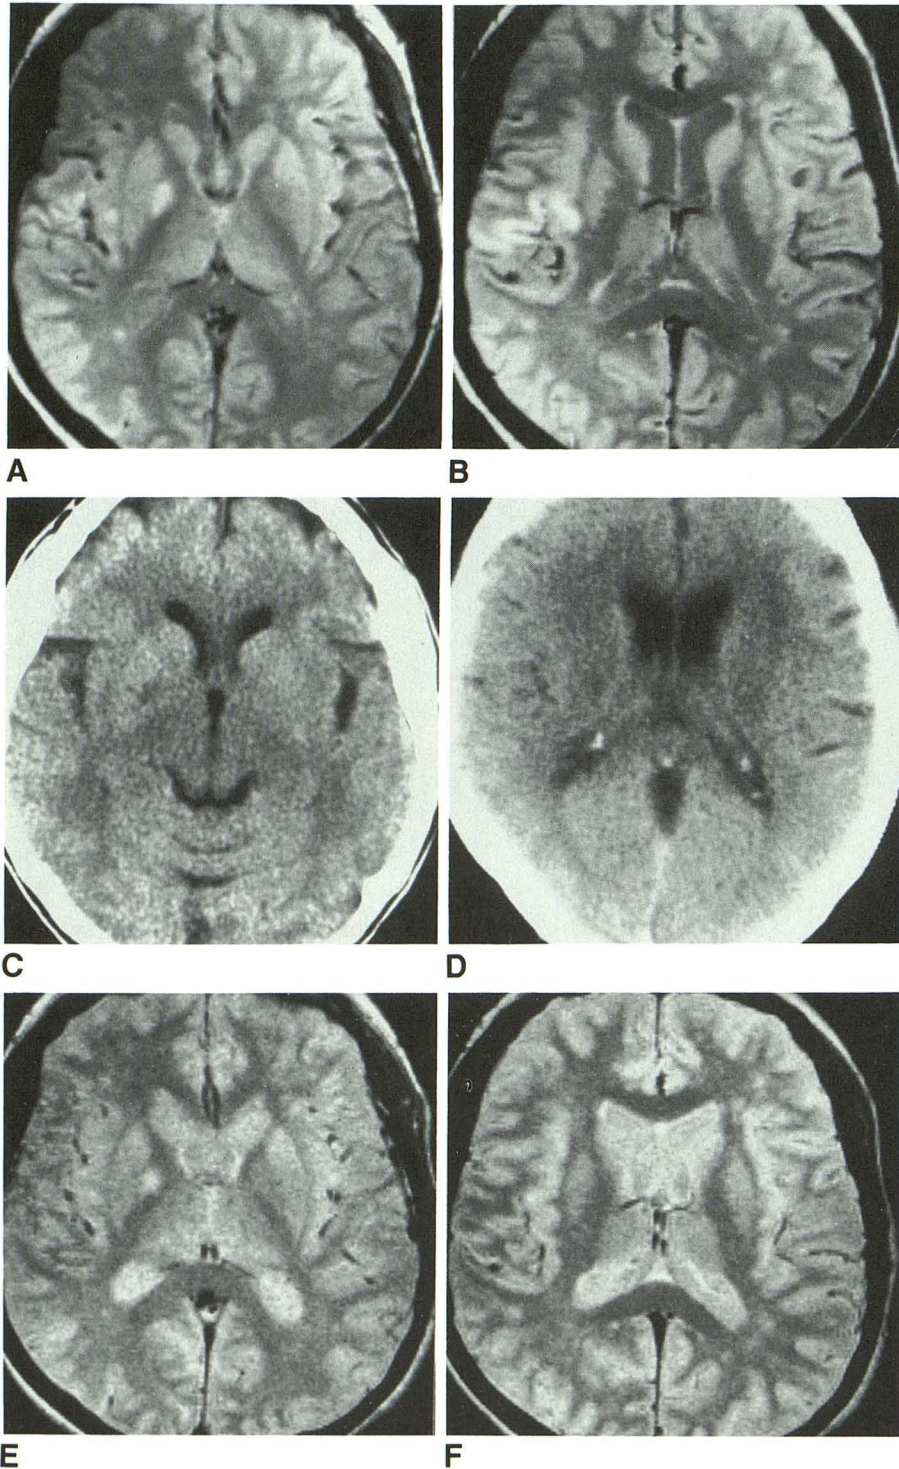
Right basal ganglia infarct and apparent right temporal cortical infarct on day 1 (A and B) with resolution of right cortical findings on follow-up examination on day 7 (C–F). Initial CT study was normal.
